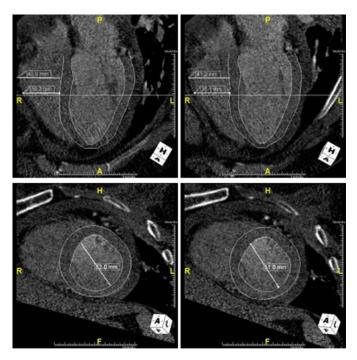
Cardiac CT (4-chamber long-axis views in top panel and mid-LV short-axis view in bottom panel) shows RV and LV measurements in end diastole during inspiratory and expiratory breath hold. The RV end diastolic diameter measures 43.0 mm in maximal diameter and 36.2 mm in mid cavity during inspiration (Figure4a, upper panel) and 41.2 mm in maximal diameter and 35.1mm in mid cavity during expiration (Figure 4b, upper panel). The LV end diastolic diameters measure 52.0 mm in mid cavity during inspiration (Figure 4a, lower panel) and 51.0 mm in mid cavity during expiration (Figure 4b, lower panel).
